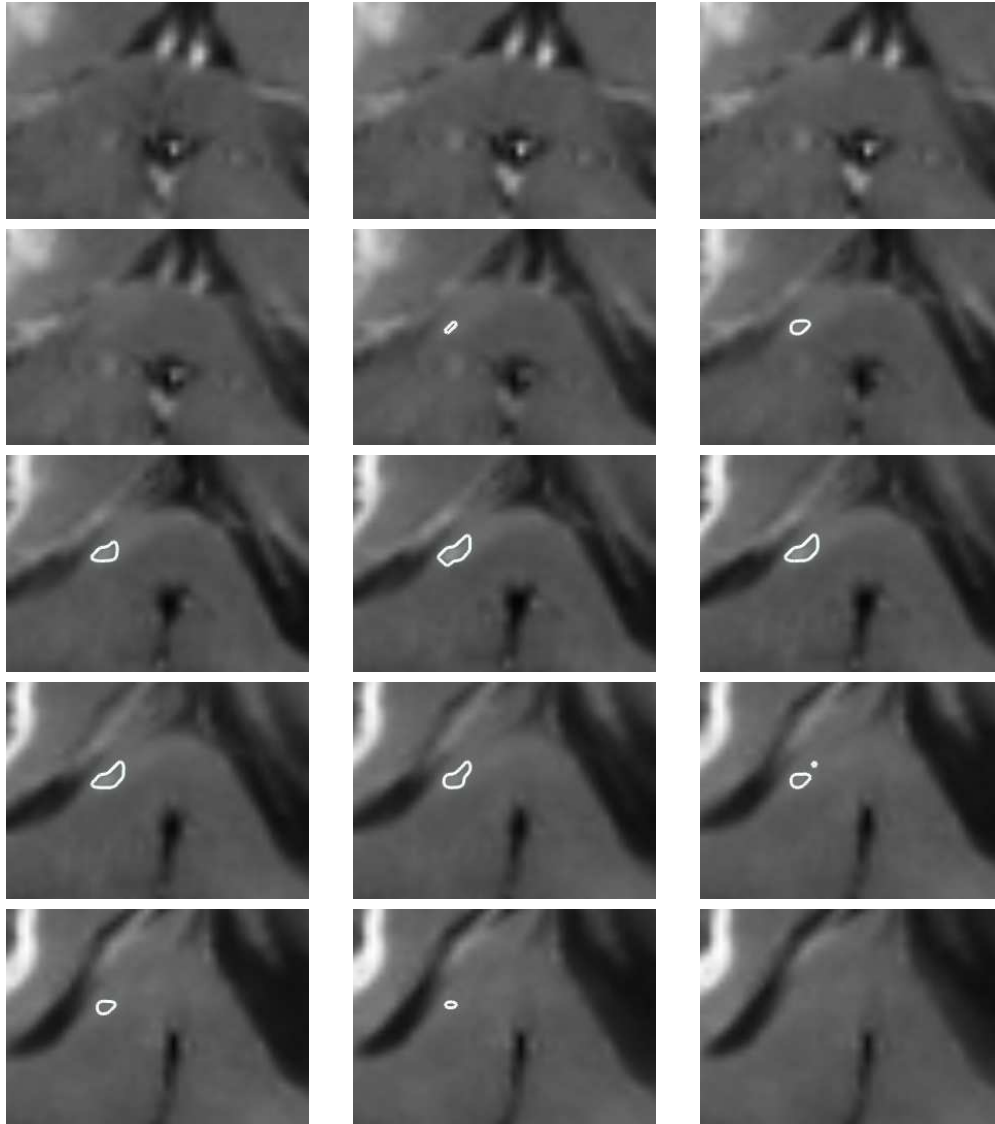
The MR image taken at the first time point for the first patient. White contour denotes the manual delineations.
